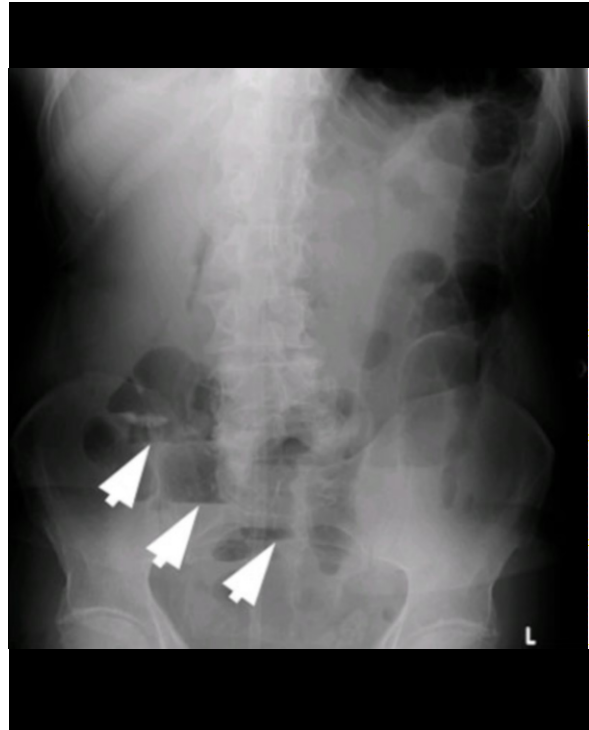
Upright abdominal radiograph shows dilated loops of small bowel, with multiple air fluid levels (arrows)
